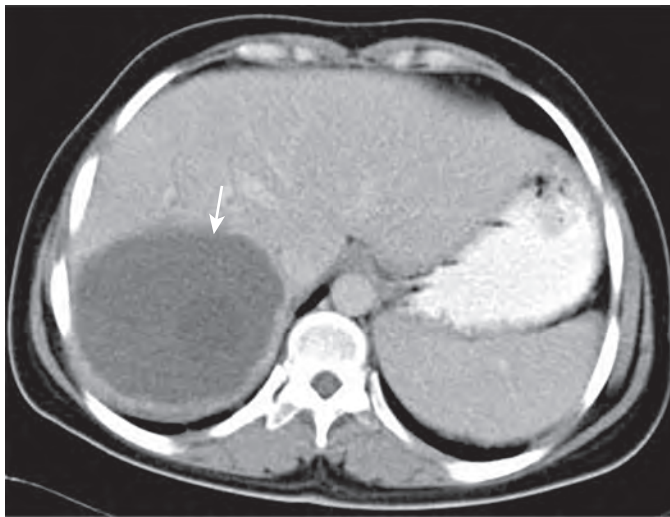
Hydatid disease: CT findings. Contrast-enhanced CT image of a patient with hydatid cyst (arrow).
